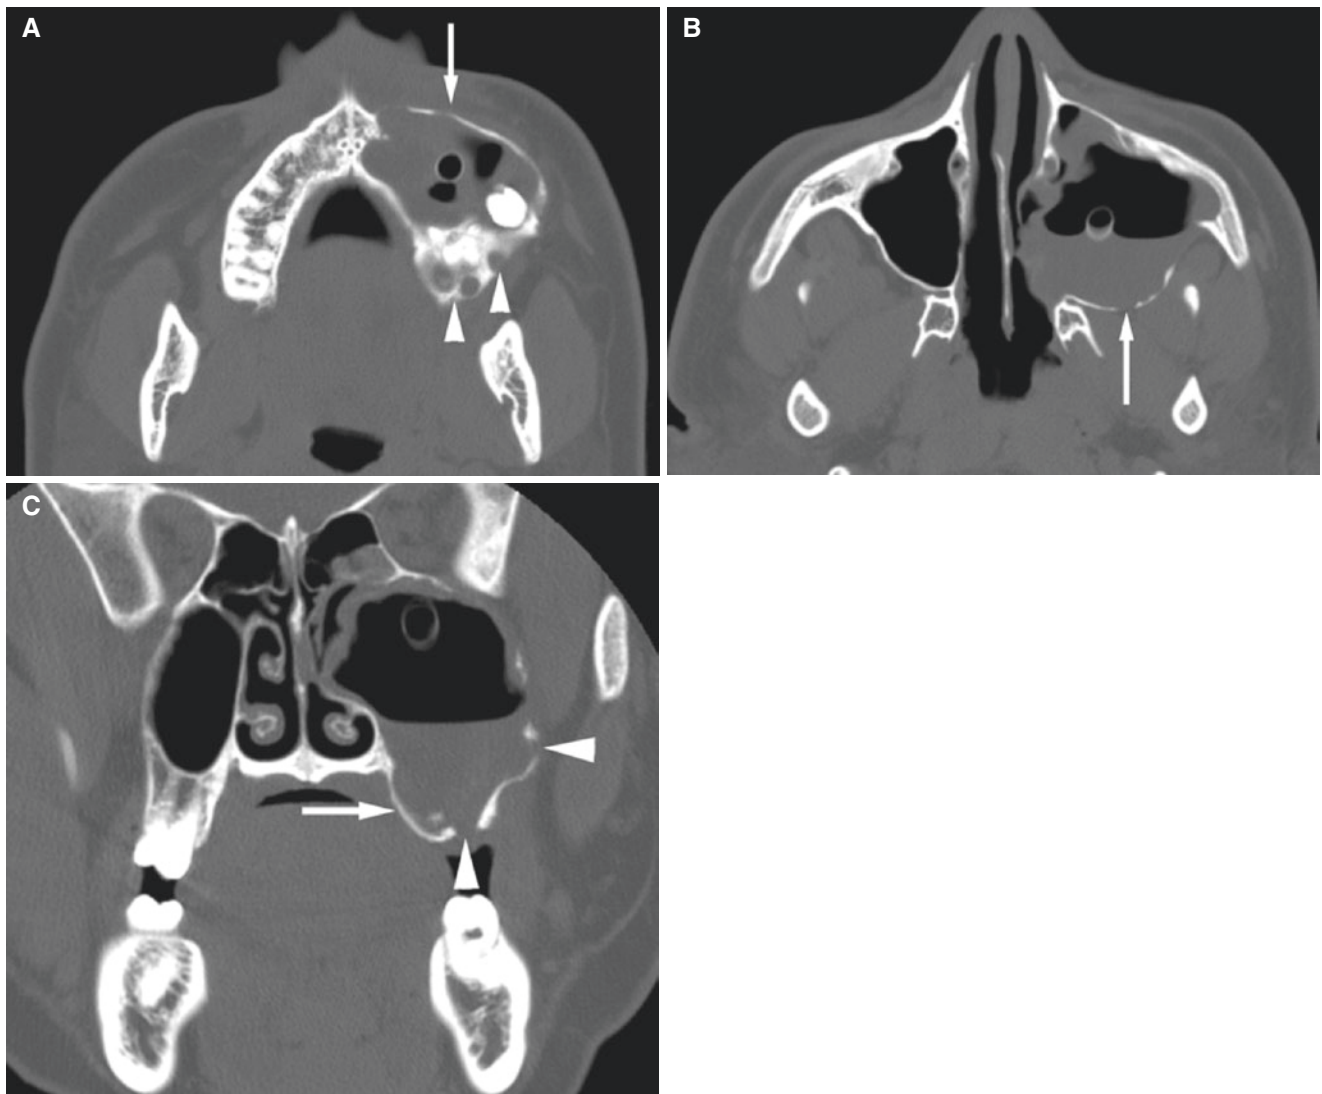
Keratocystic odontogenic tumor, maxilla; 16-year-old male with painless expansion of maxilla, complicated by sinusitis. (A) Axial CT image (after biopsy with a drain in place) shows expansive process in the left maxillary sinus (*arrow*), multilocular in posterior part
